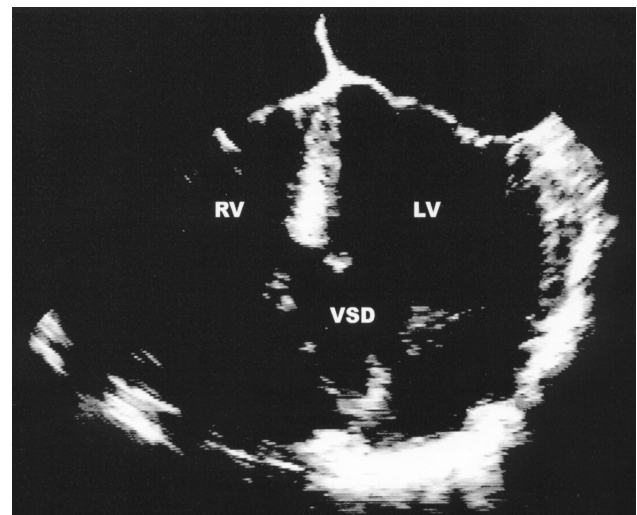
The transesophageal echocardiograph on presentation demonstrating the right ventricle (RV), left ventricle (LV) and the ventricular septal defect (VSD).
